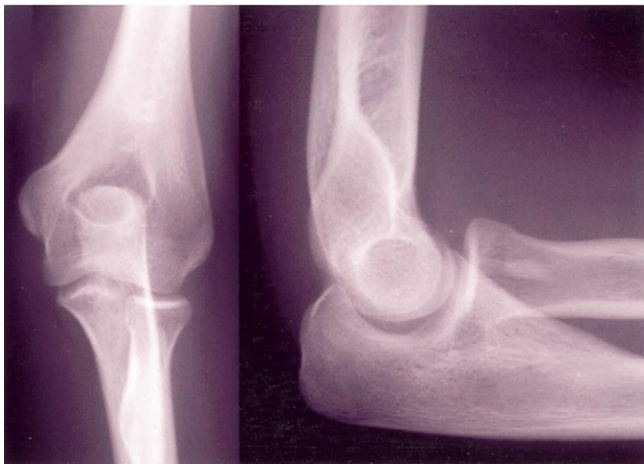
Anteroposterior and lateral X-ray of the elbow showing soft tissue swelling without any phlebolith or periosteal reaction.
